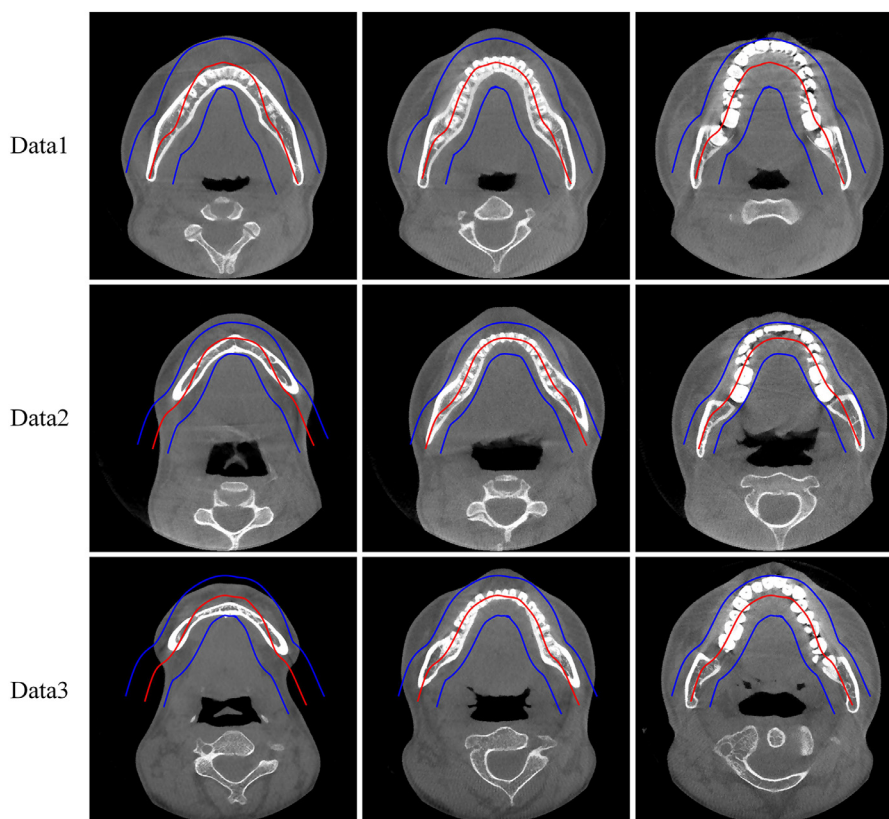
Results of the dental arch and dental arch thickness detection in three CBCT data.
